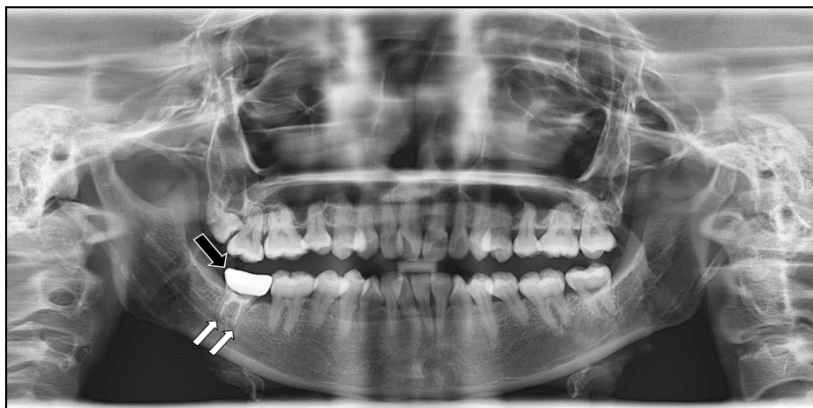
Dental orthopantomograph of the patient showing small areas of radiolucency at the tips of the root of tooth 32 (white arrows) and the metal crown (black arrow).
